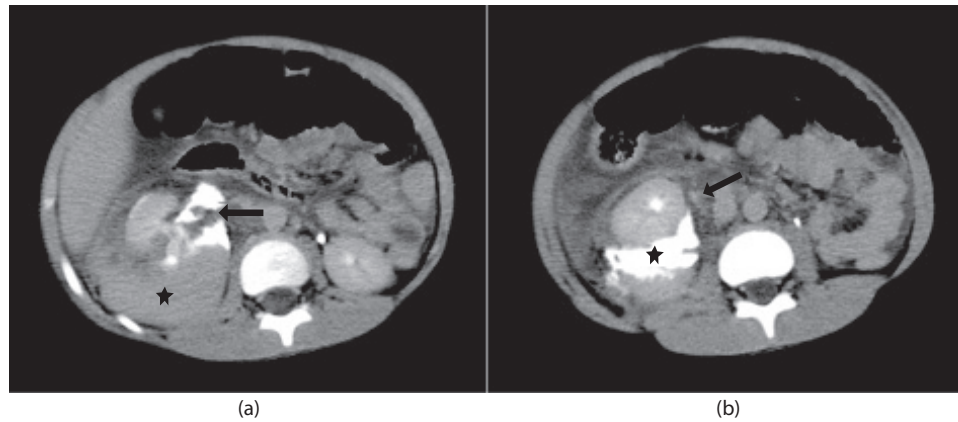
Seven-year-old male sustaining blunt renal trauma. (a) Axial CT urogram showing clot in the right renal pelvis (blue arrow) and significant hematoma posterior to kidney (blue star). (b) Axial CT urogram in the same patient showing lack of ipsilateral right ureteral opacification (red arrow) and significant posterior medial contrast extravasation/urinoma.
